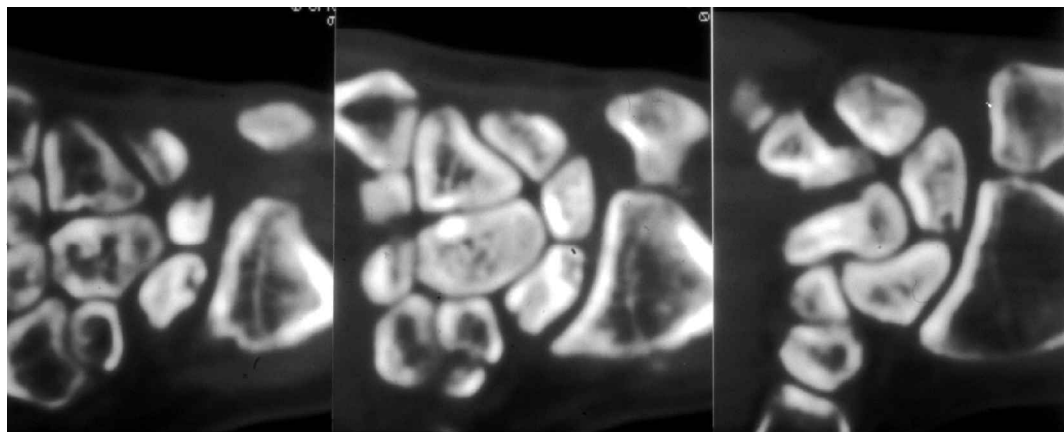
Preoperative CT of wrist showing small cysts in the proximal pole of the scaphoid and in the lunate.
